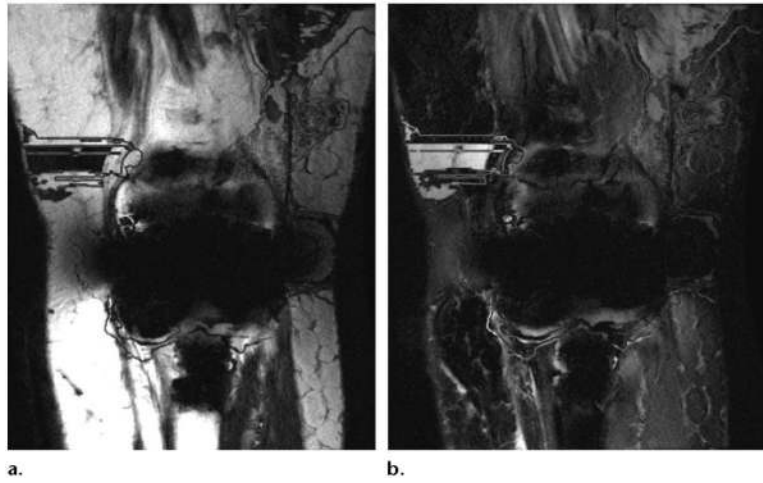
Fat-water swapping in a patient with total knee replacement. Iterative decomposition of water and fat with echo asymmetry and least-squares estimation (IDEAL; GE, Milwaukee, Wis) MR images (TR, 3000 msec; TE, 13 msec) with fat (a) and water (b) only show severe field heterogeneity and fat-water swapping.
